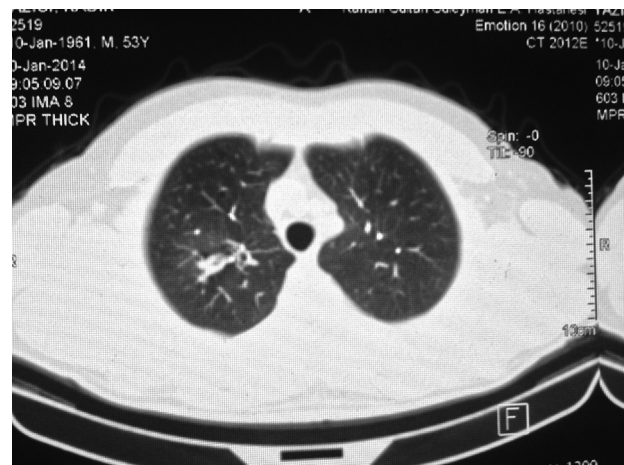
The image of cavitary lesions in thoraco-abdomino-pelvic CT during the primary diagnosis of the index case.
